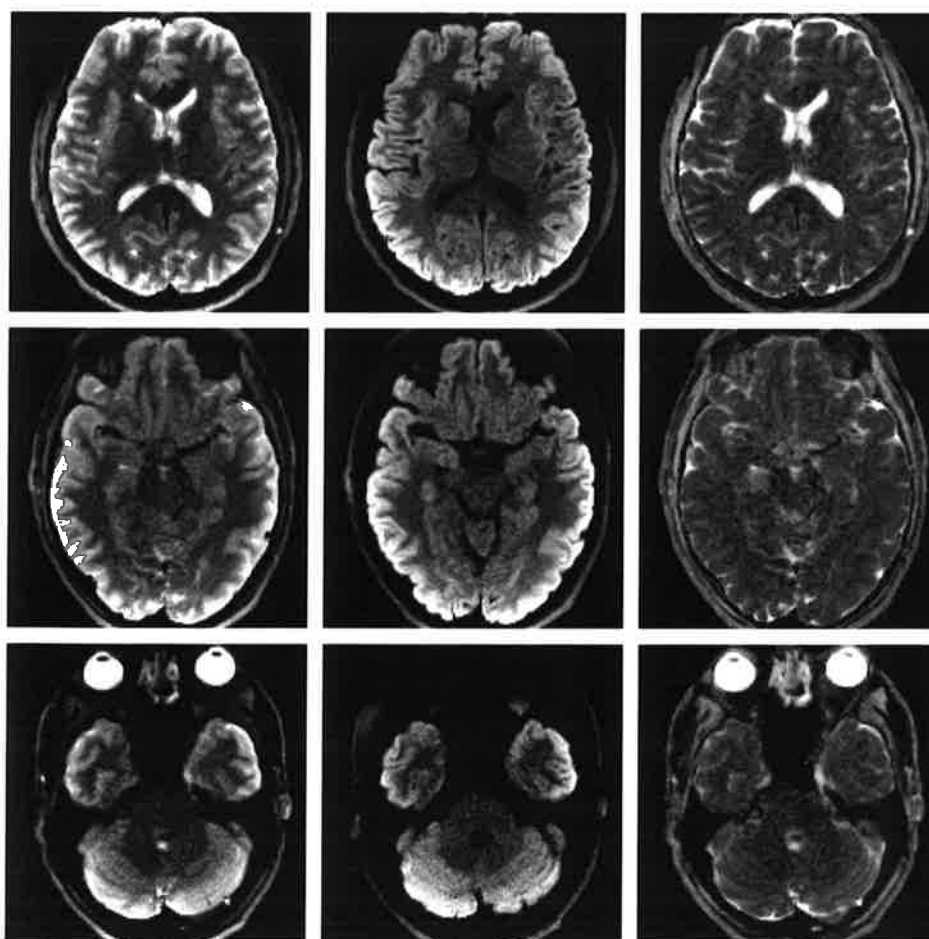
Left, Non-DW image; middle, mean DW image; and right, ADC map of the brain of a normal volunteer. The 3 selected sections were obtained by whole-brain DW STEAM MRI and the “high-resolution” protocol (see Table 1).
